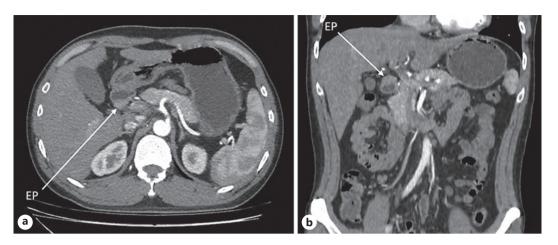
A contrast-enhanced CT findings. a Axial view showing moderate enhancing lesion similar to pancreatic parenchyma at the posterior wall of the first part of duodenum. b Coronal view showing the same mass at the superior wall of the first part of duodenum. This mass is completely separate from pancreatic parenchyma. EP, ectopic pancreas.
